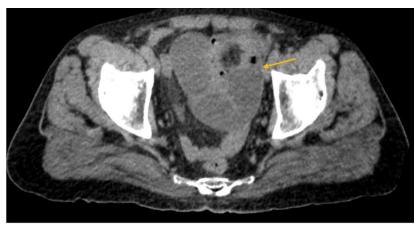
Abdominal CT scan reveals an obstruction of the small intestine with a transition zone (arrow) located in the left supravesical fossa coming into contact with the abdominal wall
